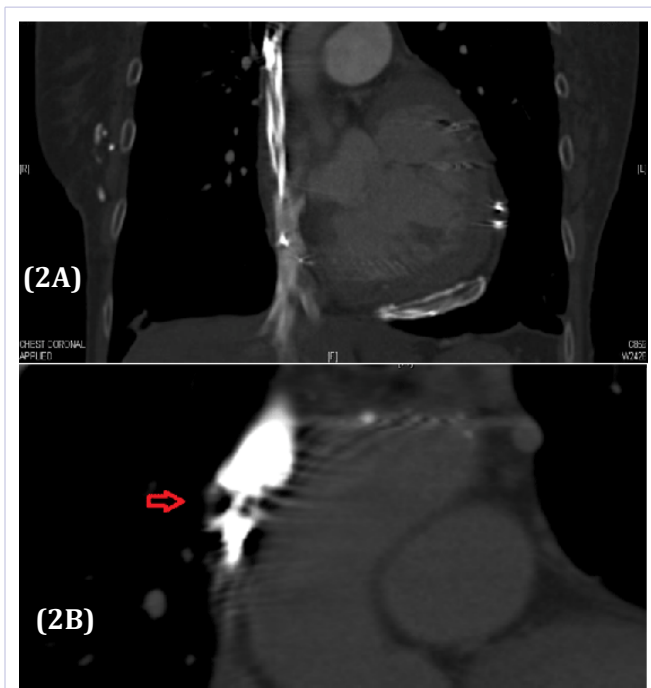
(A) Non contrast coronal section of the CT chest showing multiple pacemaker leads at the SVC and right atrium and (B) contrast coronal imaging demonstrating high grade stenosis or occlusion at the RA/SVC junction with lead artifact making distinction between high grade stenosis and occlusion difficult
